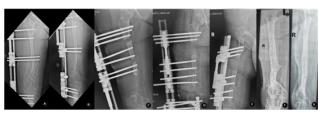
A 23-year-old woman presented with osteomyelitis of the right femur after a fall at the age of 13 years. (A,B) Anteroposterior and lateral radiographs of the femur at admission. (C) An X-ray taken 2 weeks after double-level bone transport. (D,E) Six months later, radiography showed contact at docking site and bone transport was completed. (F,G) Excellent regenerate mineralization at last visit after removal of the external fixator.
